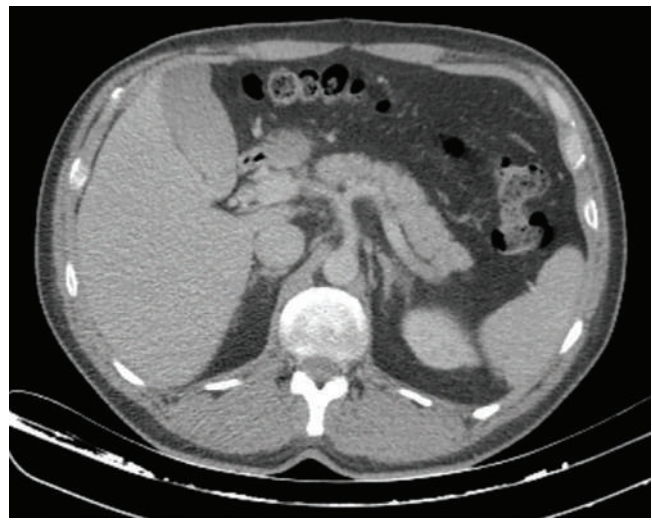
HBOT post-observation CT scan.
